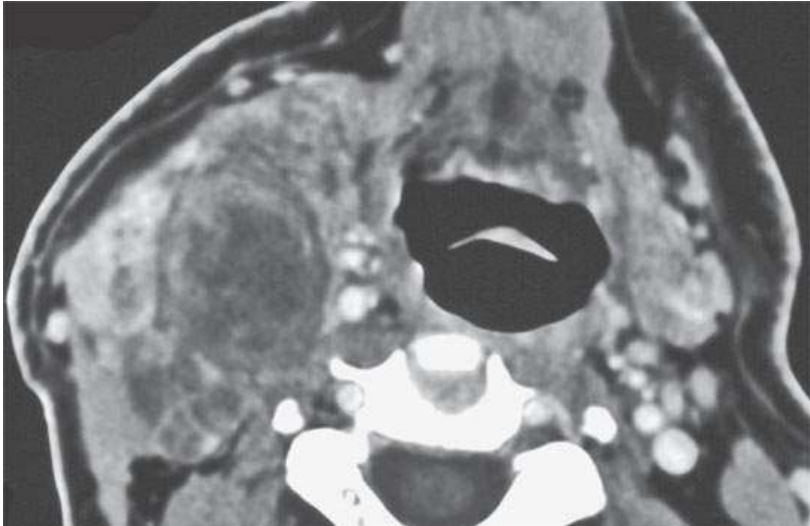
Contrast-enhanced computed tomography of a benign mixed tumor of the lateral compartment of the neck.
